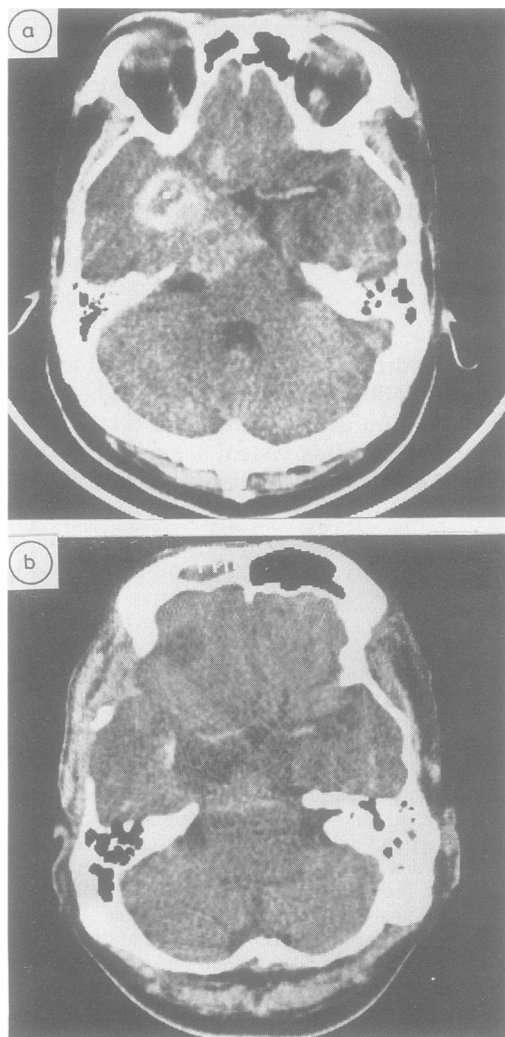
Contrast-enhanced CT scan of the brain, (a) preoperatively showing mass in the left medial temporal lobe, and the parasellar and retrosellar regions with calcification and possible haemorrhage. (b) postoperatively showing a much reduced mass-effect and little presence of residual tumour.
